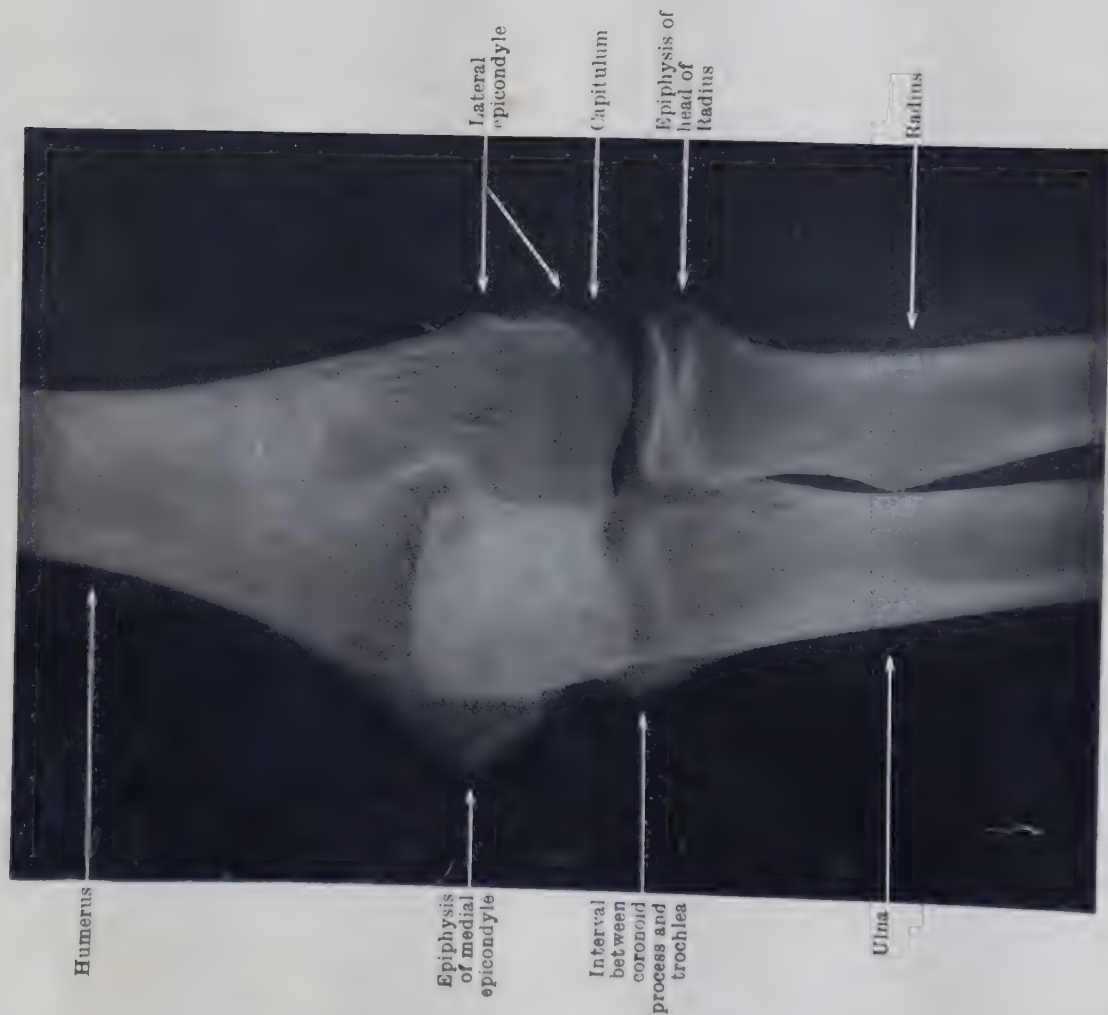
POSTERIOR RADIOGRAPH OF ELBOW OF GIRL AGED 12, SHOWING EPIPHYSES OF MEDIAL EPICONDYLE OF HUMERUS AND HEAD OF RADIUS NOT YET UNITED.
